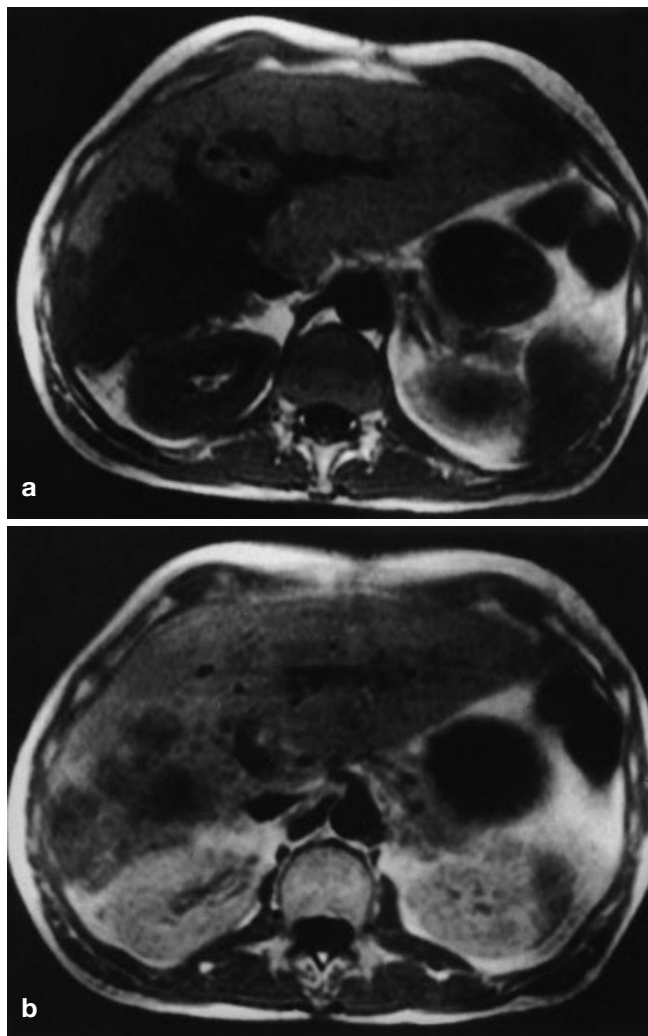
a, b Intrahepatic cholangiocellular carcinoma. a The tumor is hypointense to liver on the T1-weighted image. b Pooling of contrast within the tumor, reflecting the large amount of fibrous tissue, is seen on the delayed, gadolinium-enhanced image
